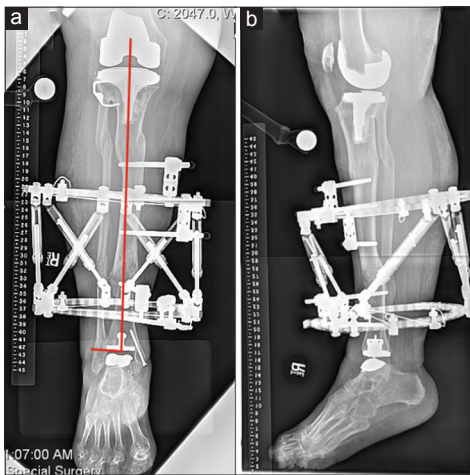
(a) Anteroposterior and (b) lateral radiographs of the right leg at end-distraction before removal of the Taylor Spatial Frame. Drawn in red is the mechanical axis showing the corrected lateral distal tibial angle measuring 88°
